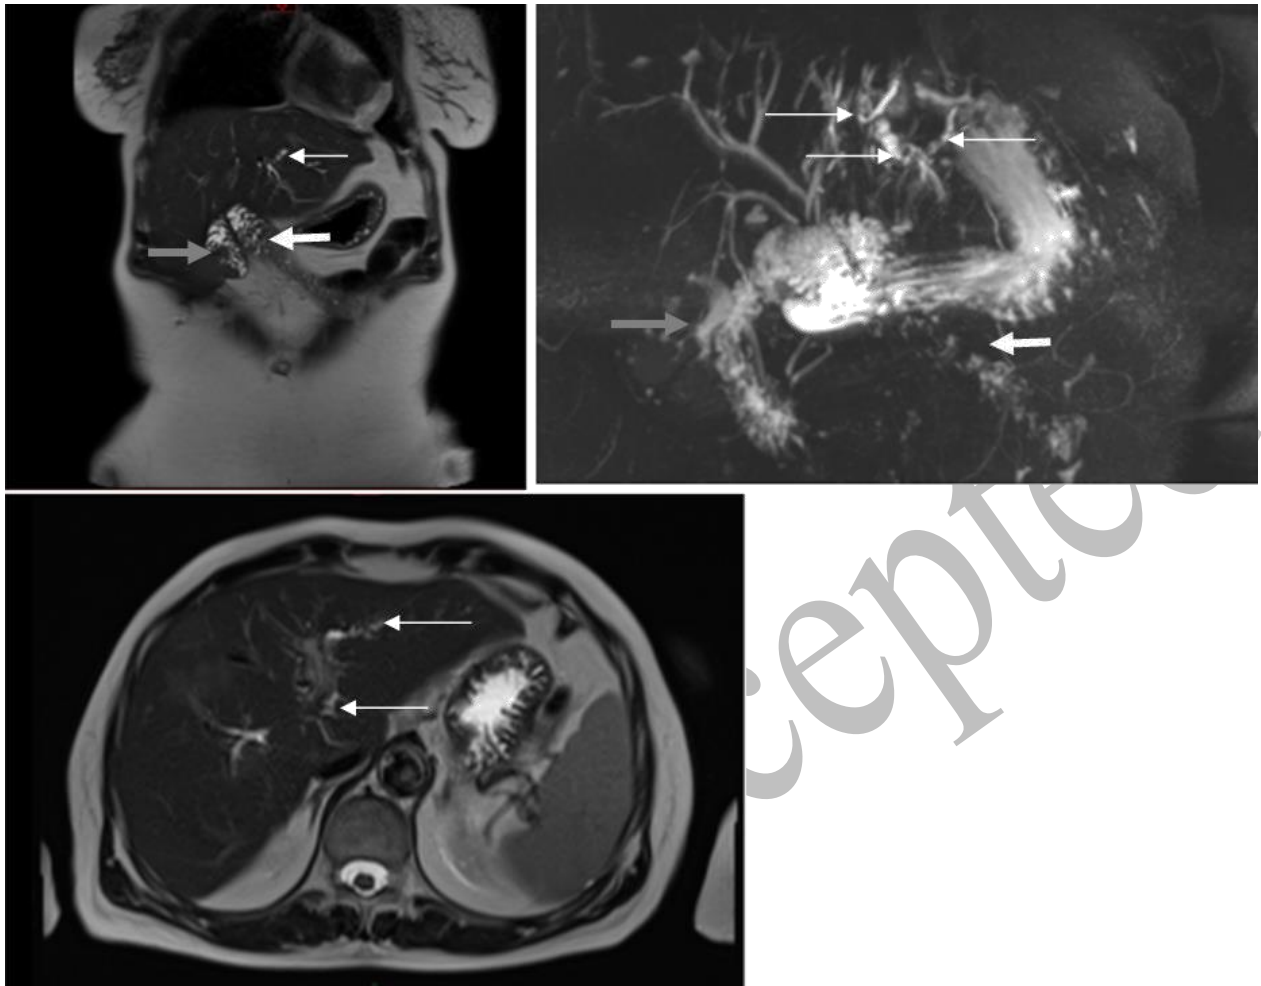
Abdominal magnetic resonance imaging and magnetic resonance cholangiopancreatography made before problem resolving operation: afferent jejunal limb of the non-Roux-en-Y hepaticojejunostomy (pointed by thick white arrow), efferent jejunal limb (pointed by gray arrow) and intrahepatic biliary calculi (pointed by thin white arrows)
